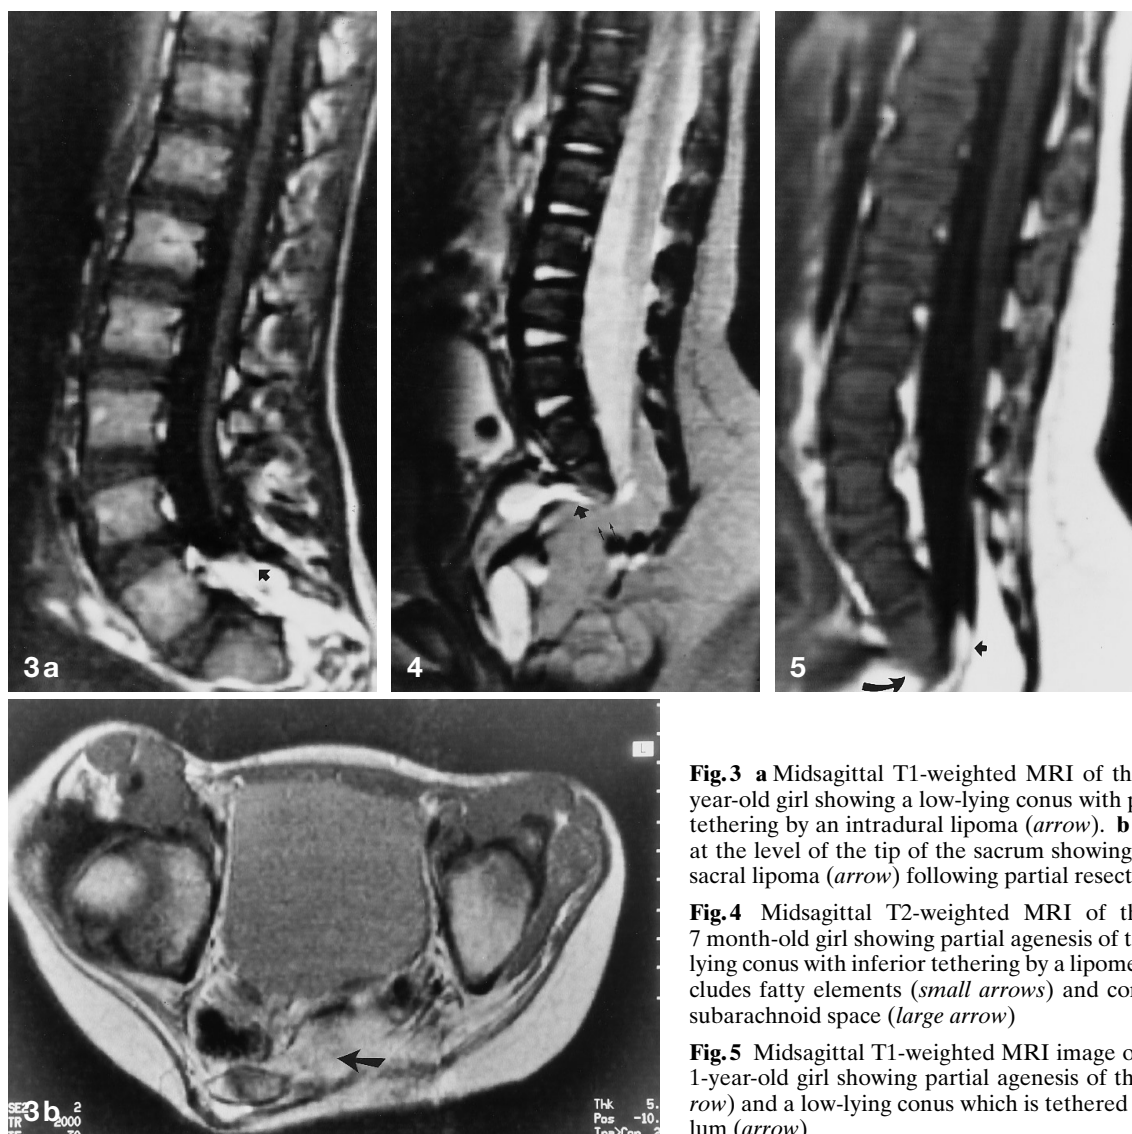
a Midsagittal T1-weighted MRI of the spinal cord in a 9-year-old girl showing a low-lying conus with posterior and inferior tethering by an intradural lipoma (*arrow*). b Transverse T1 image at the level of the tip of the sacrum showing a persisting left presacral lipoma (*arrow*) following partial resection
